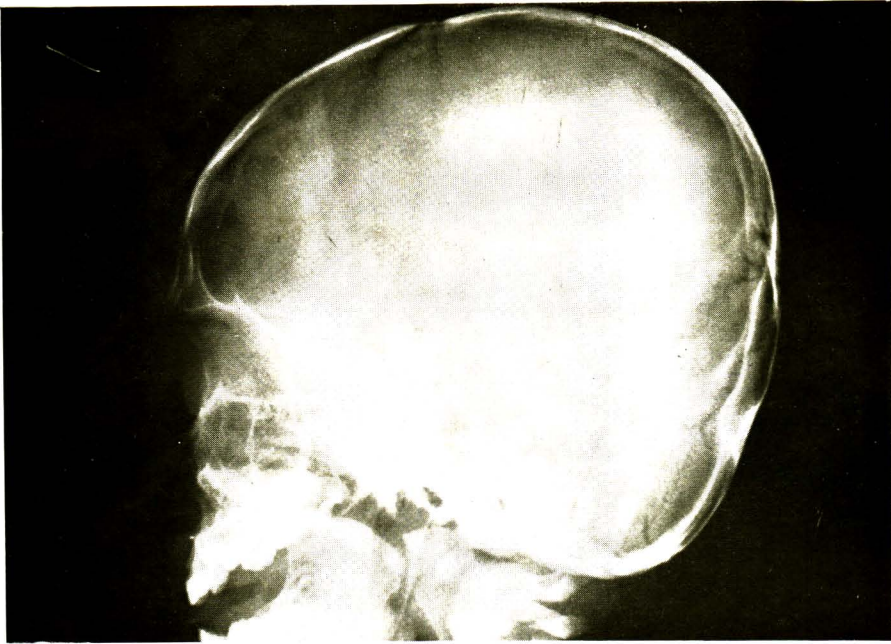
Nasofrontal type of frontoethmoidal encephalomeningocele, lateral roentgenogram showing the cranial defect. Note the nasal bone below the defect.
